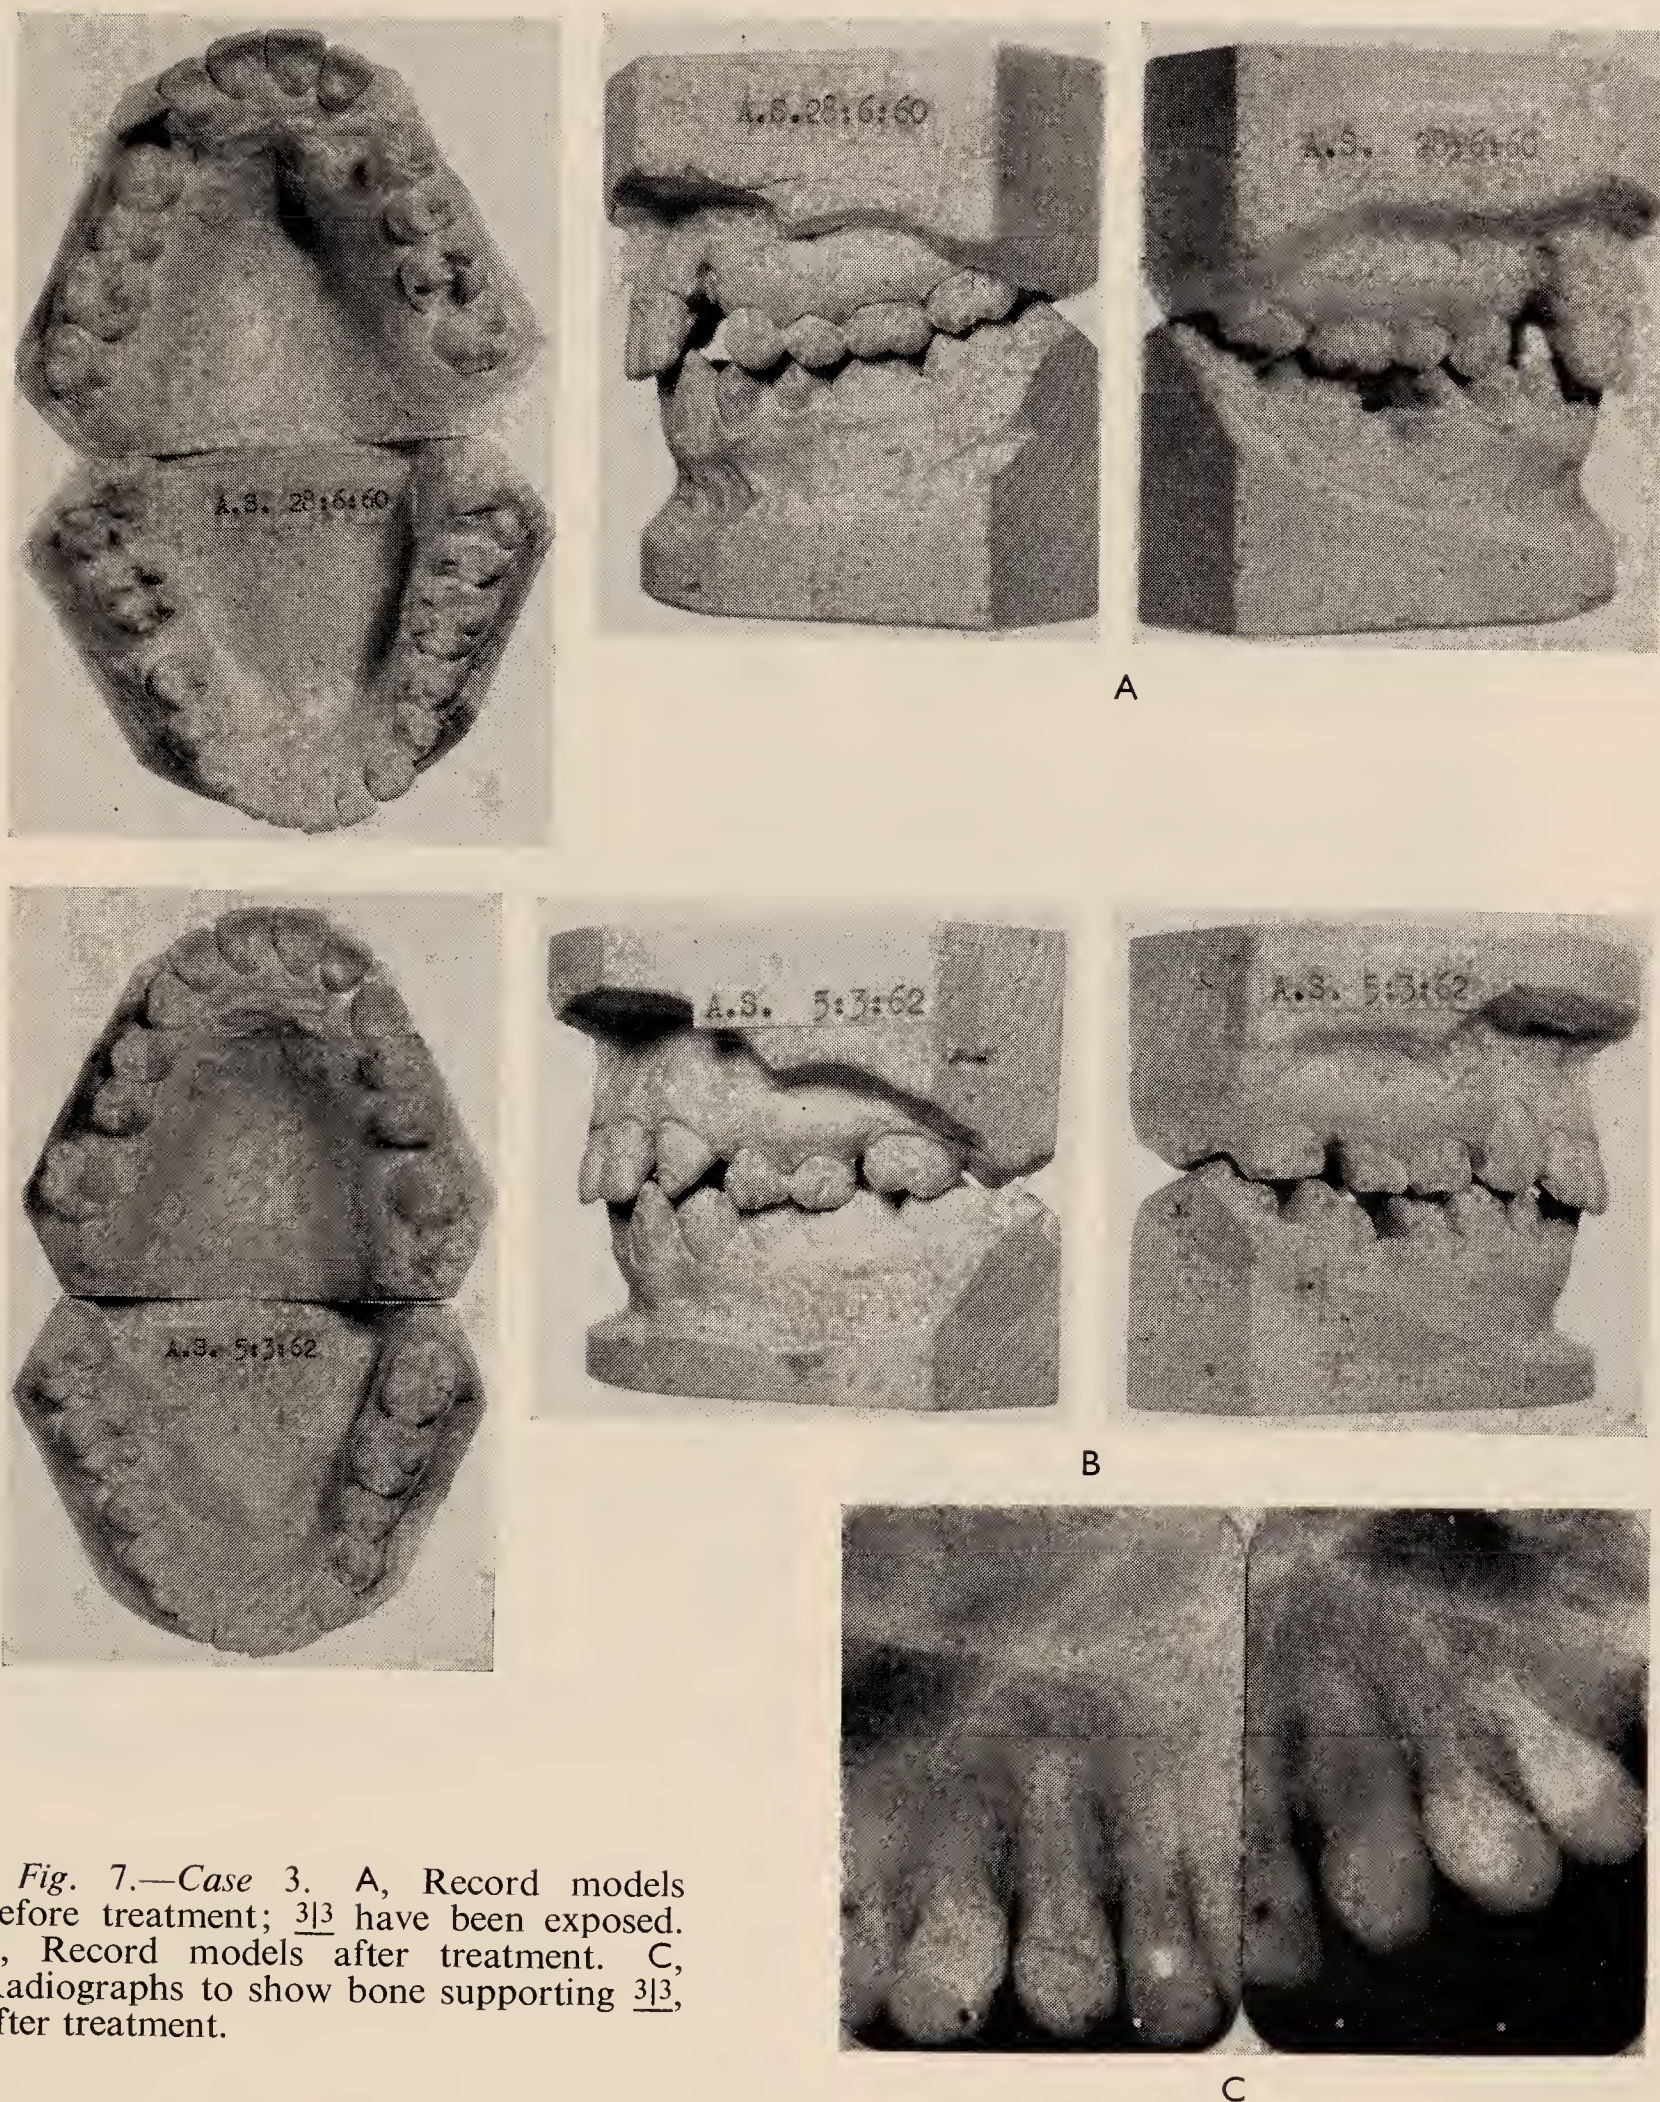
Case 3. A, Record models before treatment; $\underline{3|3}$ have been exposed. B, Record models after treatment. C, Radiographs to show bone supporting $\underline{3|3}$, after treatment.
